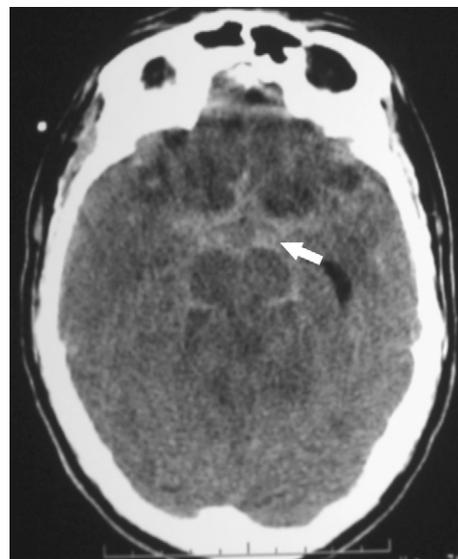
Coccidioides* meningitis. Axial non-enhanced CT scan shows abnormal increased density in the suprasellar cisterns caused by dense inflammatory exudate (white arrow).
